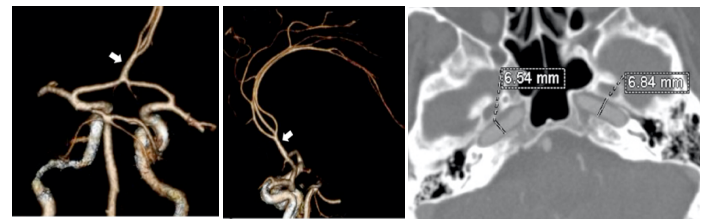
62-year-old man with azygos anterior cerebral artery. Volume rendering oblique axial (a) and sagittal (b) CT images show azygos anterior cerebral artery A2 segment. Axial CT image (c) shows widening of the carotid canal.
